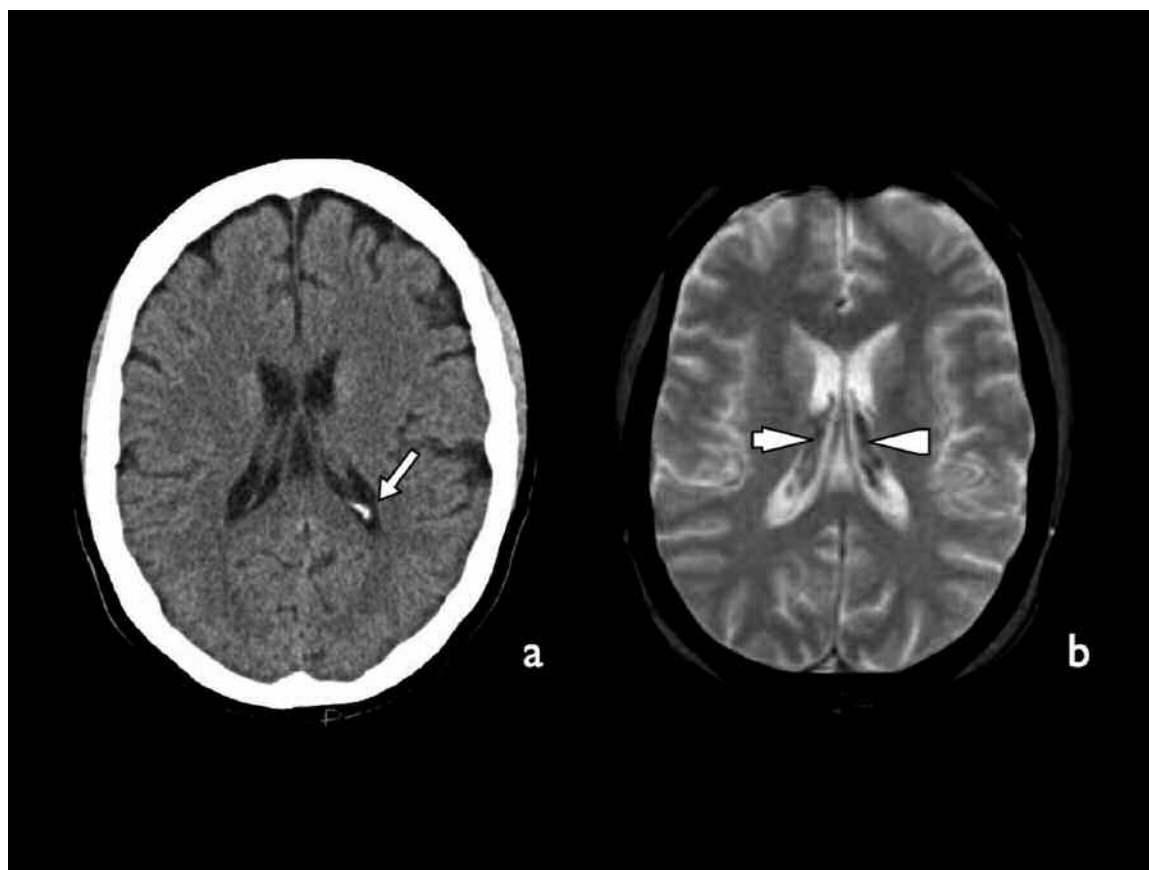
Axial nonenhanced CT image (a) and MRI T2* image (b) at the same level showing a marked low signal at the choroid plexus (b, arrowheads) not related to the calcifications — a normal finding — seen on CT image (a, arrow).
